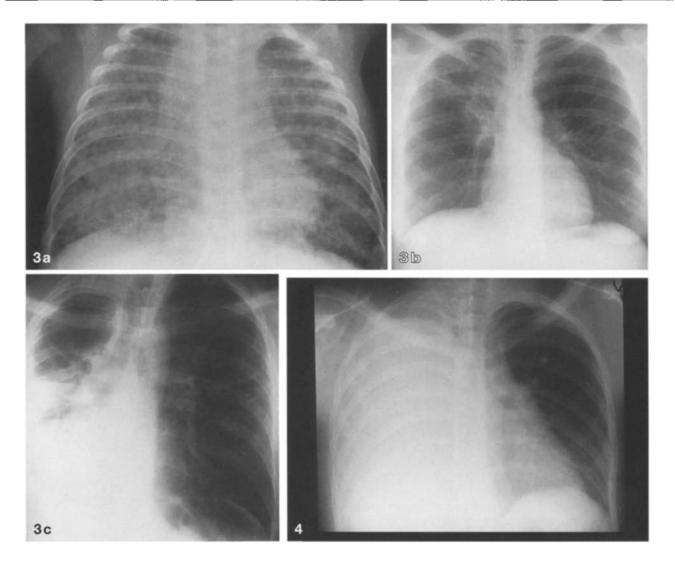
Transmission of MTb within a family. a Anteroposterior chest radiograph of a 3-month-old male infant shows innumerable small ill-defined nodular opacities throughout both lungs, consistent with miliary tuberculosis. b Posteroanterior chest radiograph of the child's mother shows patchy opacity in the right upper lobe with strands of opacity extending to the hilum. c Posteroanterior radiograph of the child's father shows severe cavitation and destruction of the right lung
